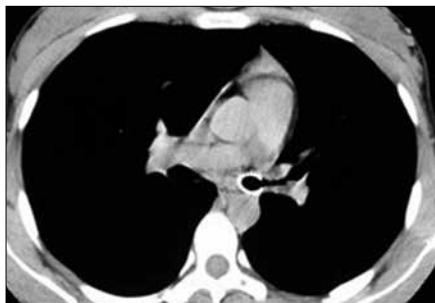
Postoperative multislice computed tomography image of the chest shows complete inflation of the stent.
